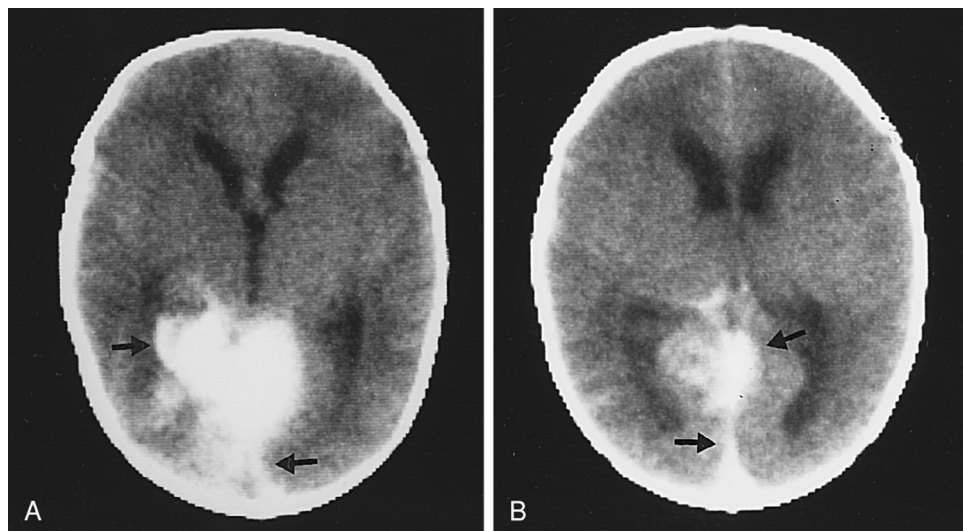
A and B, Generalized tonic seizures, lethargy progressing to coma, and an irregular respiratory pattern were observed in a 1-day-old full-term infant. Computed tomography scan demonstrates a hyperdense lesion emanating from the falx and tentorium (arrows) caused by a traumatic tear of the tentorium, which resulted in hemorrhage from the straight sinus.
